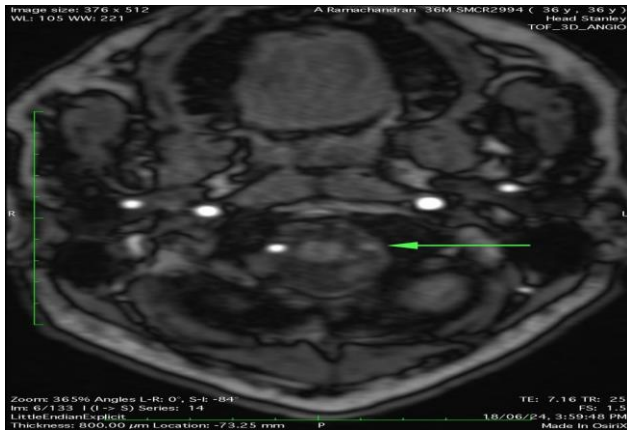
CT angiogram-left vertebral artery not seen.
